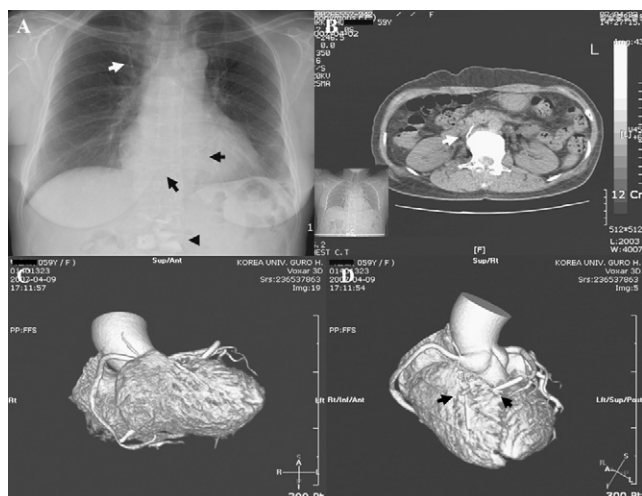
(A) Chest and thoracolumbar spine X-ray showing opacification on the 12th thoracic and 1st lumbar vertebrae after percutaneous vertebroplasty (arrow head) and three fish-bone like materials in the cardiac chamber (black arrows) and a linear opacity in the right upper lung (white arrow). (B) Abdominal computed tomograph showing cement leakage outside the involved vertebral body and in the venous system after percutaneous vertebroplasty (white arrow). Coronary computed tomographic angiograph disclosing the longest fish-bone like material that pierced the right ventricular cavity obliquely (C) and multiple cardiac perforations by fish-bone like materials that pierced the right ventricular free wall (black arrows) (D).
